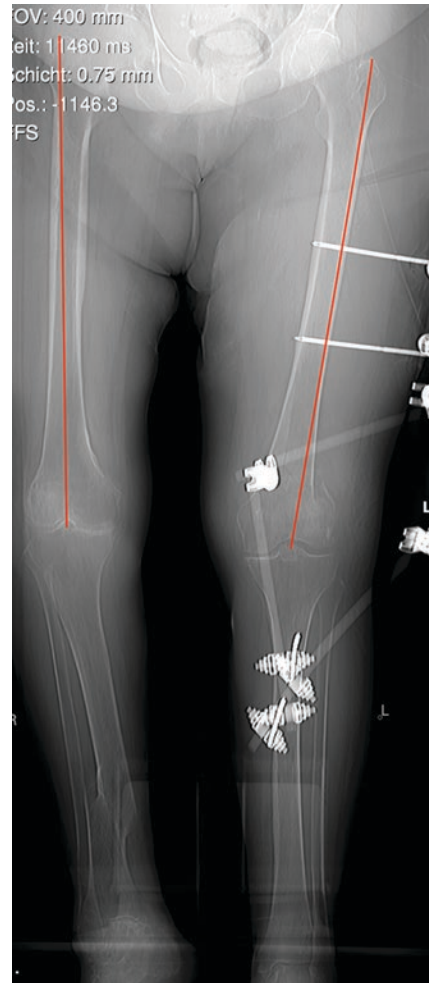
CT scout can be used for surgical planning. The correct leg length can be calculated from the opposite limb
